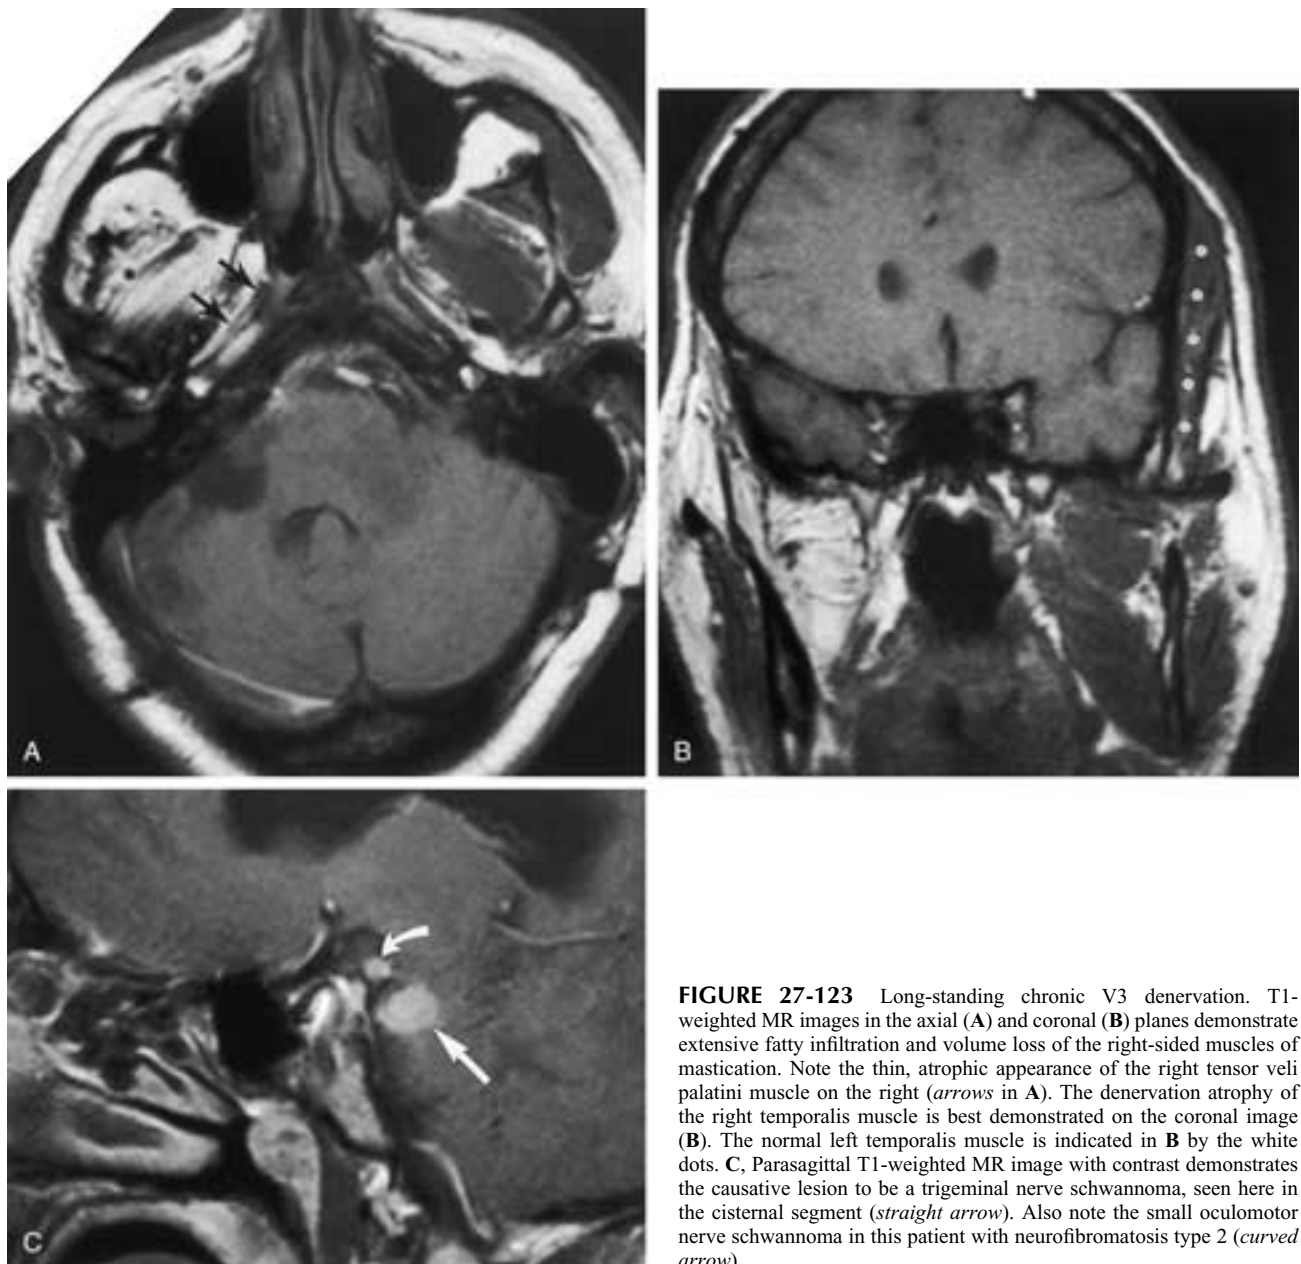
Long-standing chronic V3 denervation. T1-weighted MR images in the axial (A) and coronal (B) planes demonstrate extensive fatty infiltration and volume loss of the right-sided muscles of mastication. Note the thin, atrophic appearance of the right tensor veli palatini muscle on the right (*arrows* in A). The denervation atrophy of the right temporalis muscle is best demonstrated on the coronal image (B). The normal left temporalis muscle is indicated in B by the white dots. C, Parasagittal T1-weighted MR image with contrast demonstrates the causative lesion to be a trigeminal nerve schwannoma, seen here in the cisternal segment (*straight arrow*). Also note the small oculomotor nerve schwannoma in this patient with neurofibromatosis type 2 (*curved arrow*).
